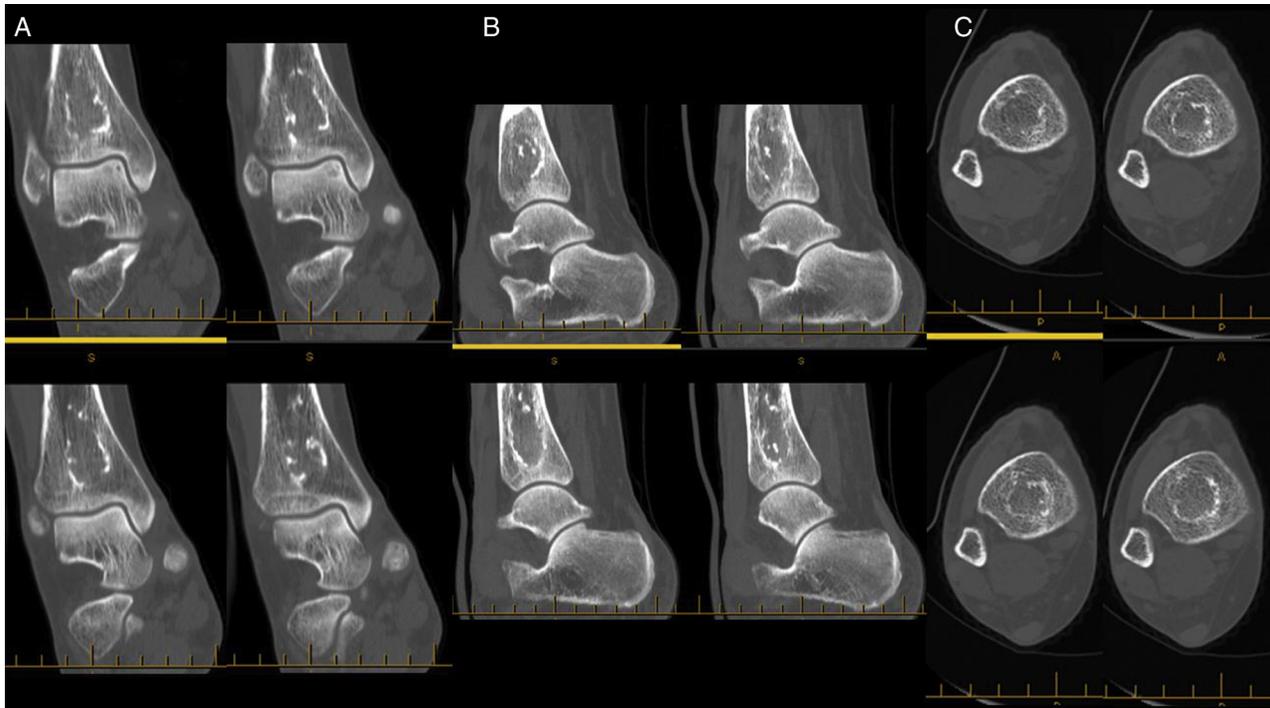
Computed tomography study showing lesions of avascular necrosis in the coronal (A), sagittal (B), and transverse (C) slices of the diaphyseal-metaphyseal junctions of the right tibia.
